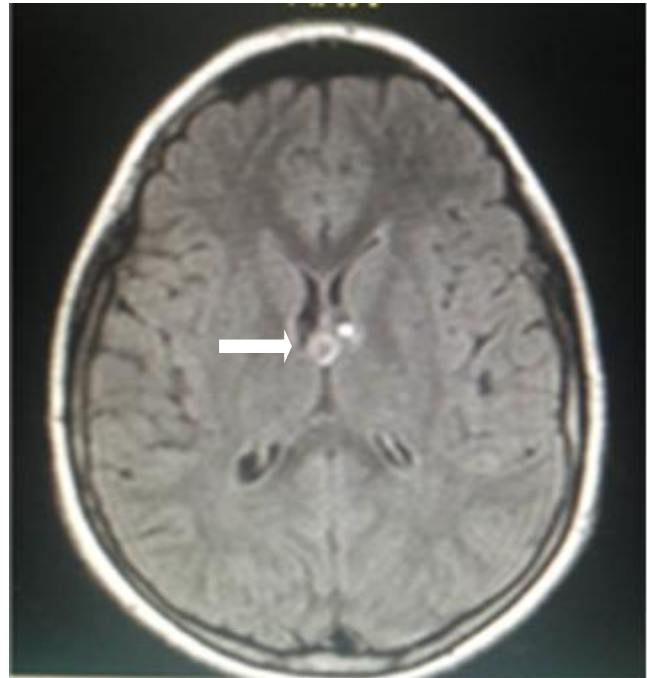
Axial brain computed tomography
